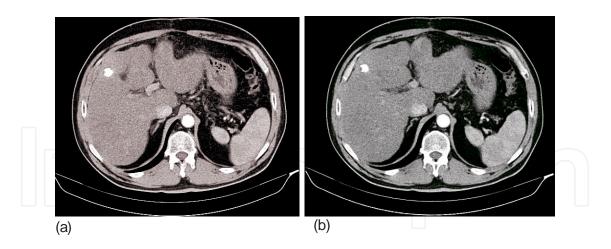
a. Lipiodol present inside the lesion one month after TACE. CT examination. We remark the hyperechoic, homogenous, dense aspect of the lipiodol concentrated inside the lesion. b. The same case, follow-up 3 months after treatment. We remark the persistence of lipiodol inside the lesion and a discrete decrease of tumor dimensions.
